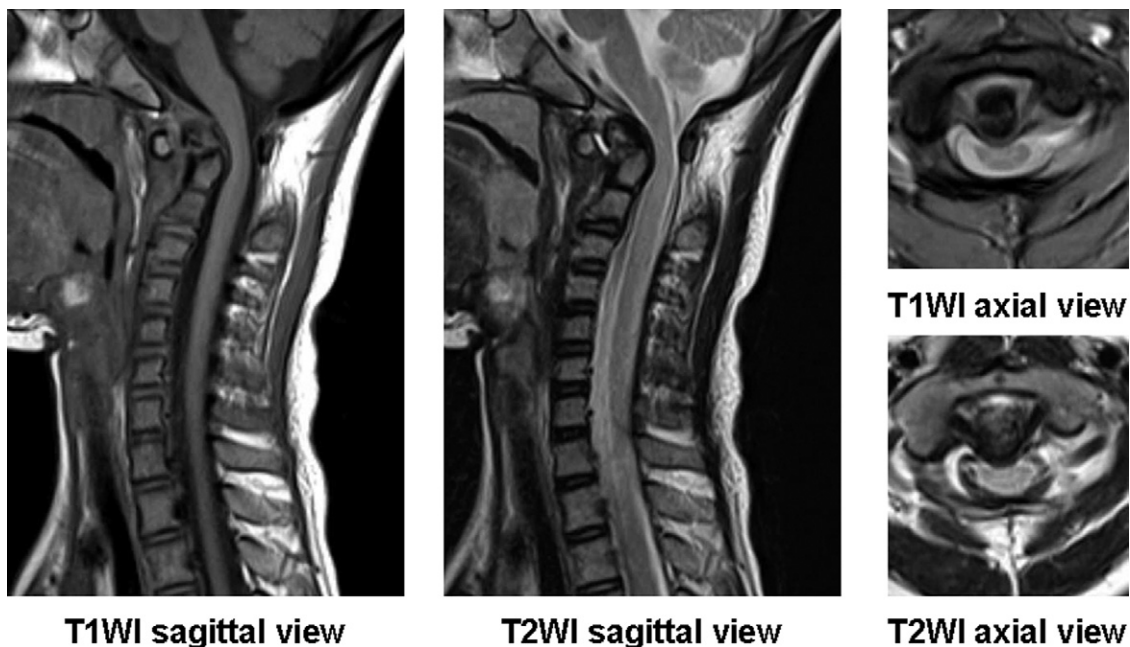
Preoperative magnetic resonance image (T1WI: T1-weighted image, T2WI: T2-weighted image) in case 1. The spinal cord snaked through into the spinal canal, but high-intensity change of the spinal cord on the T2WI was not observed.
